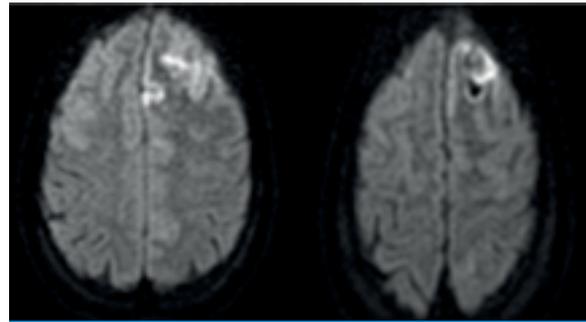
DWI images: Showing diffusion restriction in the left frontal lobe
